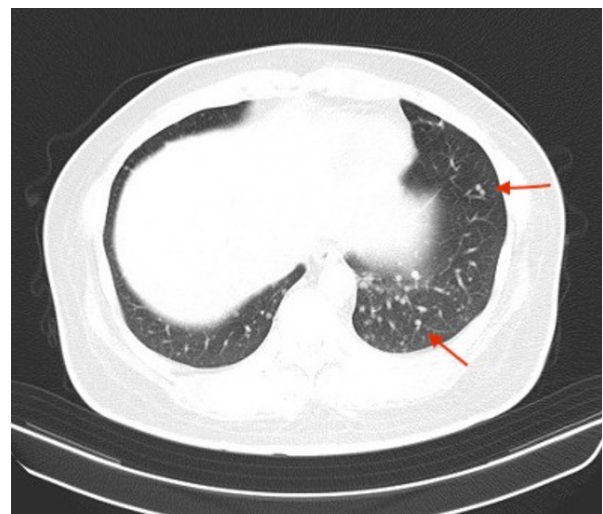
Chest CT. Multiple pulmonary nodules are shown by red arrows.ing intensity of HMW-MAA-positive cells in primary ALM lesions.
